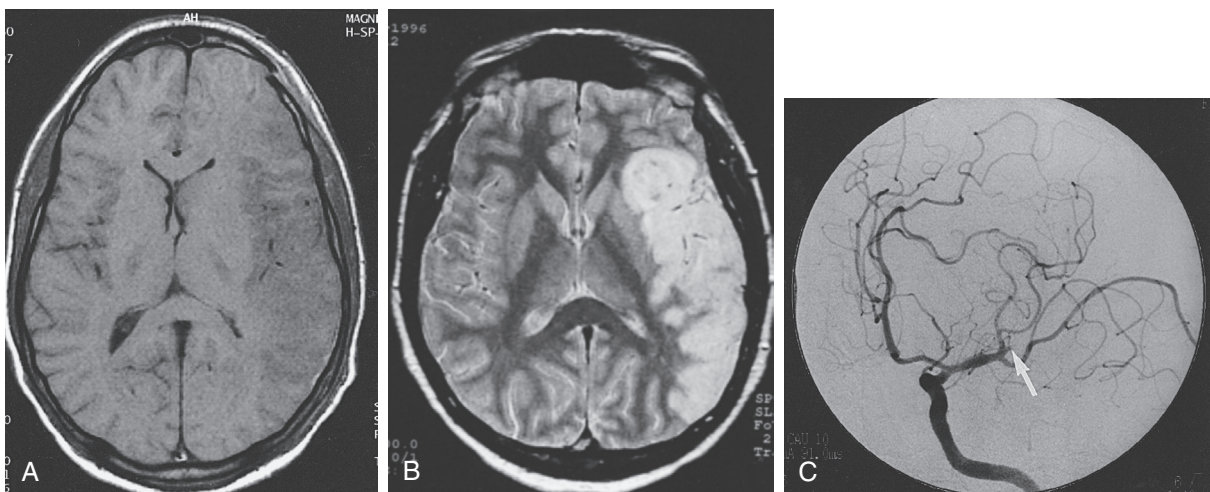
■ Infarct. Axial T1-weighted (A) and T2-weighted (B) magnetic resonance imaging (MRI) scans of patient being evaluated for stroke. Initial computed tomography scan (not shown) was normal. Magnetic resonance imaging demonstrates an area of cytotoxic edema involving distal left middle cerebral artery territory. Edema is hypointense to brain on T1-weighted image and hyperintense to brain on T2-weighted image. Left internal carotid artery angiogram (C) demonstrates occluded branch of left middle cerebral artery (arrow). Within the proper time frame, intraarterial thrombolysis would be a method of management for this patient.
